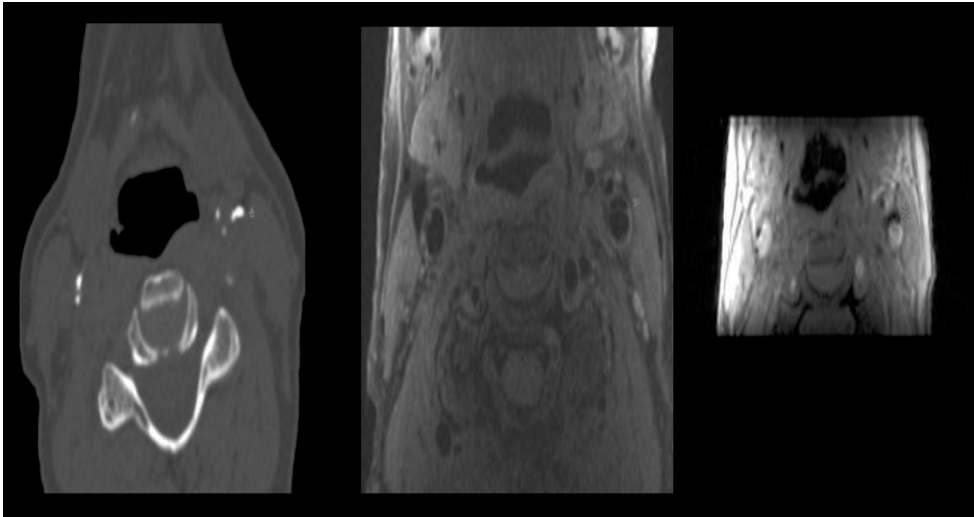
Example of calcification in the left carotid artery bifurcation (indicated by the red star) on CT (left image) and on MRI (middle image; PDw-FSE-BB sequence, and right image; magnitude image of the 3D-phase contrast sequence).
